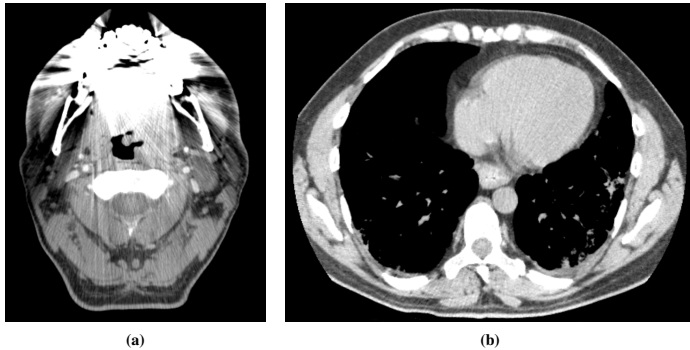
Examples of streaking artifacts in CT data. (a) Neck dataset with dental metal implants. (b) Thorax dataset with slight streaking artifact in the heart region, possibly due to motion.
